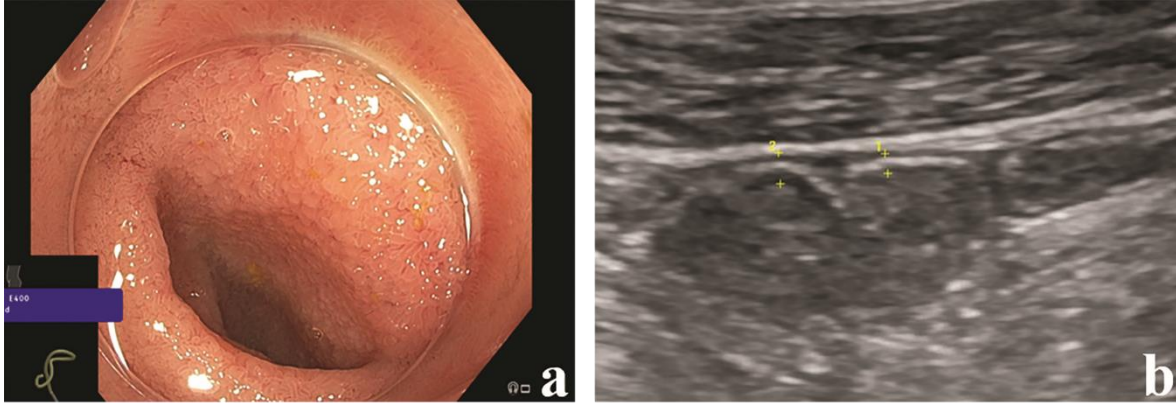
Terminal ileum in endoscopic (a) and sonographic (b) remission. Bowel wall thickness is measured between the yellow calipers in the anterior wall in longitudinal section.
